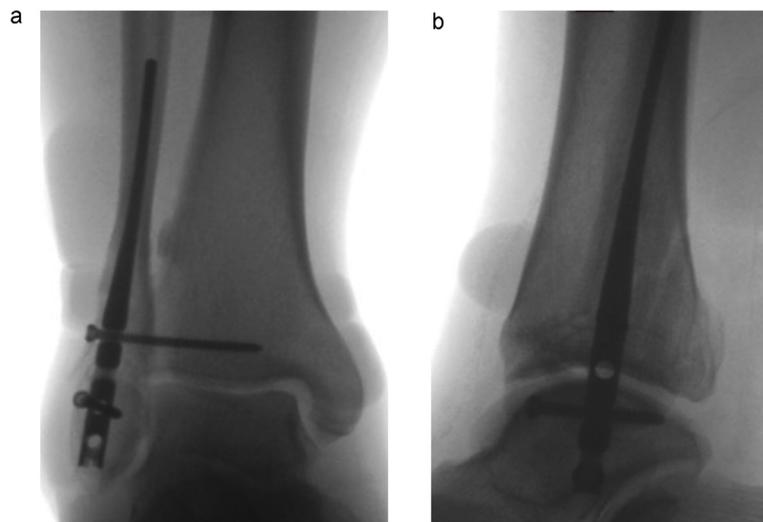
Intra-operative anteroposterior (a) and lateral (b) fluoroscopy one day post-injury demonstrating an anatomically reduced medial malleolar fracture and anatomical mortise reduction post fibular nail insertion. The outline of fracture blistering can be seen on both radiographs.
